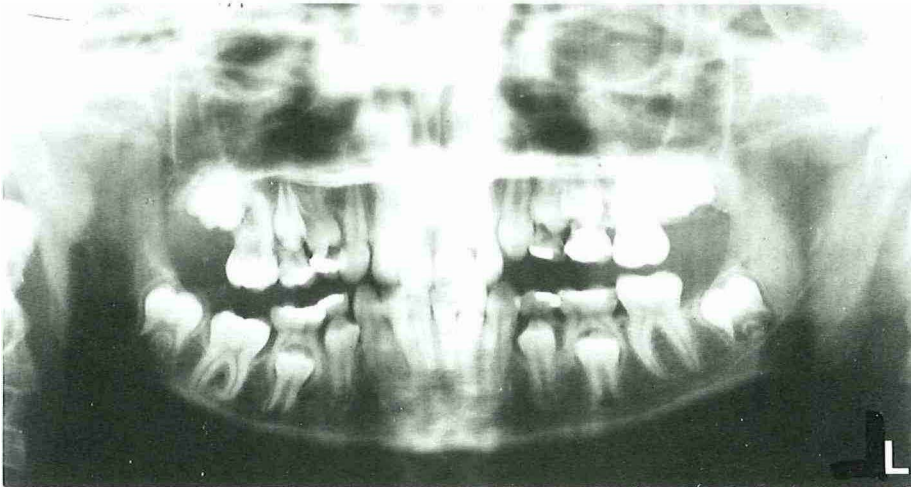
Orthopantomogram of a 12-year-old girl showing secondary retention of the left first and second deciduous molars and right first permanent molar in the mandible.
